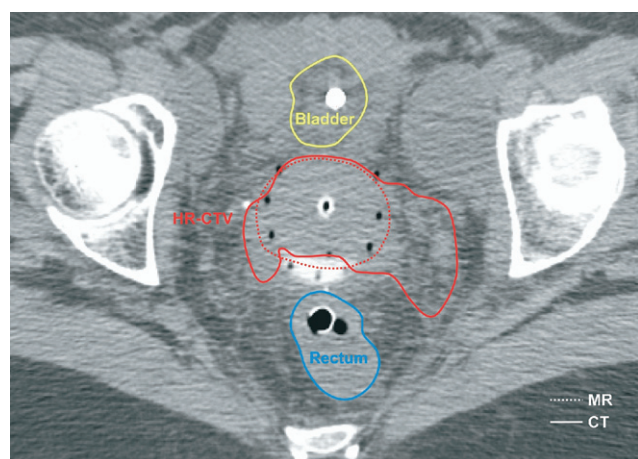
Axial computed tomography slice of pelvis immediately superior to ring applicator depicting parametrium in patient with Fédération Internationale de Gynécologie et d'Obstétrique Stage IIB cervical cancer. Both magnetic resonance imaging (solid line) and computed tomography (dotted line) contours are superimposed. Bilateral inconsistencies with regard to parametrial extension of high-risk clinical target volume are revealed. Computed tomography contours confirm significantly increased lateral extension of parametrial tissues contoured compared with magnetic resonance imaging contour. Therefore, clinical examination and magnetic resonance imaging before brachytherapy are critical to avoid unnecessarily contouring uninvolved parametrial tissue.
